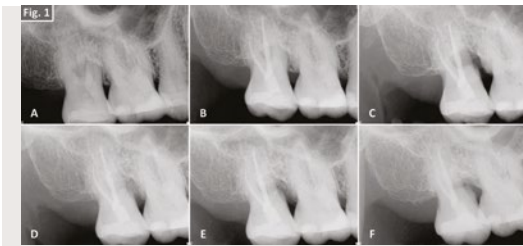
(Case 1) Periapical radiograph showing a radiolucent lesion in the furcation region of tooth 17 (A) and post-root canal treatment (B). Intra-operative radiograph following the mesiobuccal root resection of tooth 17 (C). Immediate postoperative radiograph after guided tissue regeneration (D). Radiographs at one month (E) and four years (F), demonstrating bone remodelling and tooth preservation.
